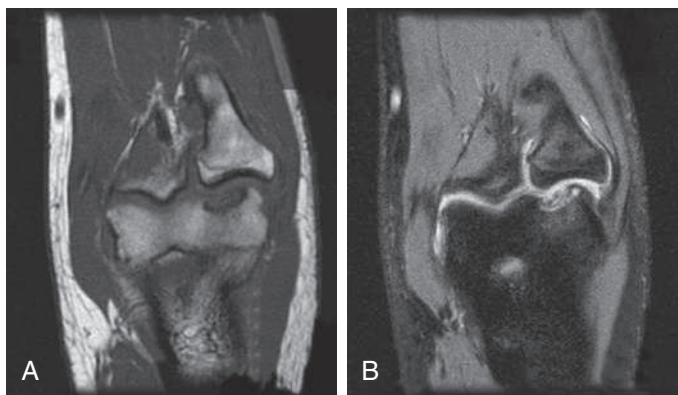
T1 (A) and T2 (B) coronal MRI images of the elbow depicting Panner disease of the elbow.
